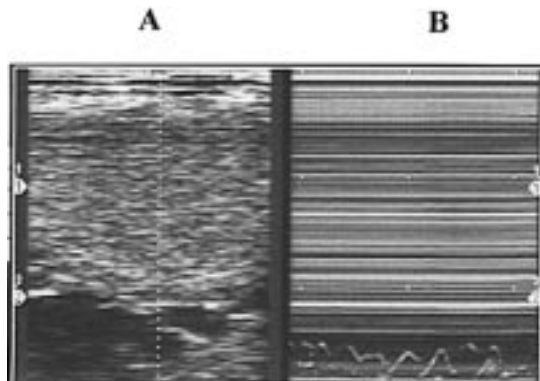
Ultrasound image of left hemiscrotal area in an asymptomatic 22-year-old man, obtained with a 7.5-MHz transducer. A B-mode image (A) shows the left testis and lymphangiectasia. An M-mode image (B) shows the wave pattern characteristic of the filaria dance sign.
